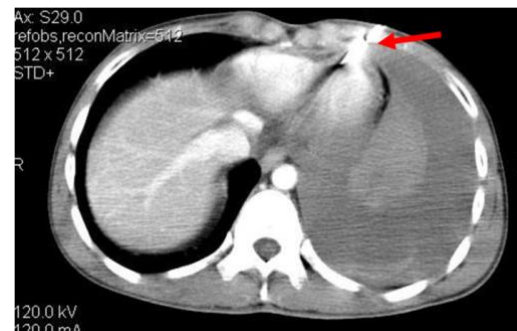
CT Scan showing left hemothorax with trajectory artefact of the flying feather (arrow)
